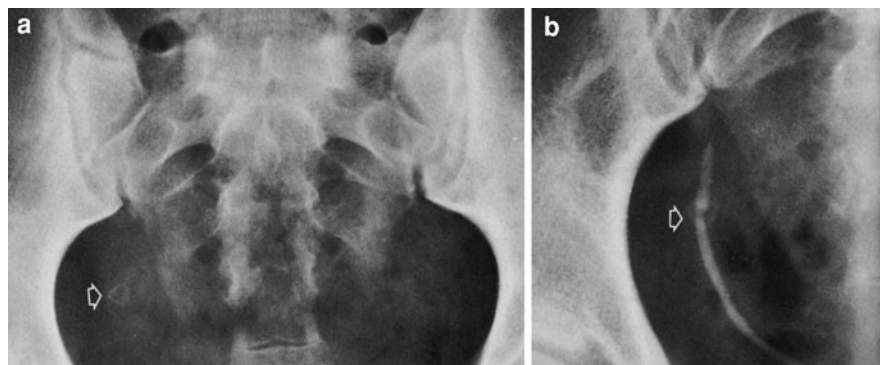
Appendicolith mimicking a ureteral stone in a patient with hematuria. a Plain abdominal radiograph demonstrates a calcification in the region of the lower right ureter (*arrow*). b Excretory urogram shows the appendicolith (*arrow*) as separate from the nonobstructed right ureter
